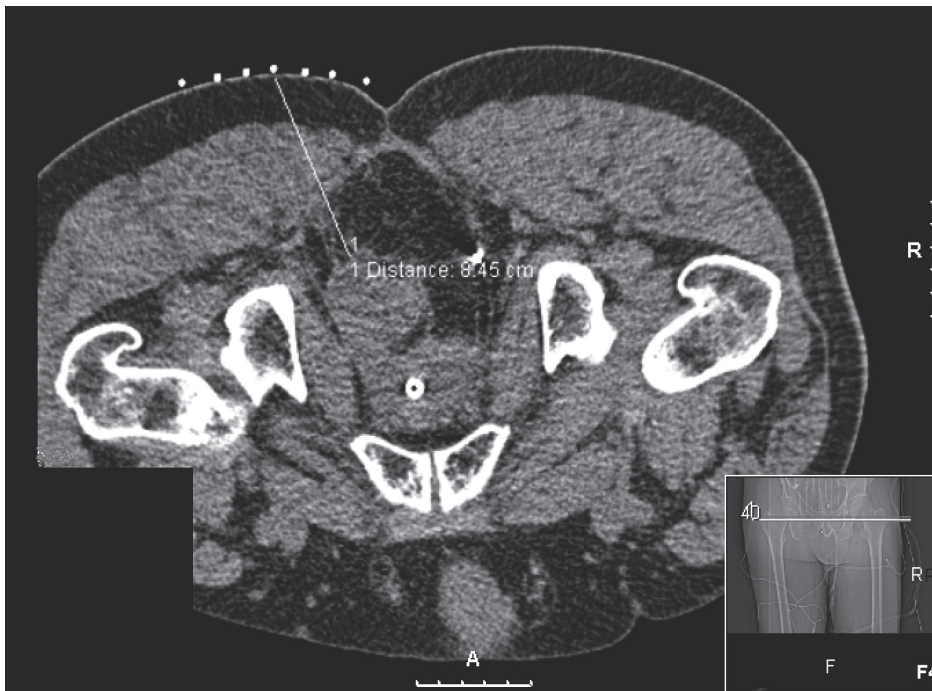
RFA probe positioning under CT guidance
